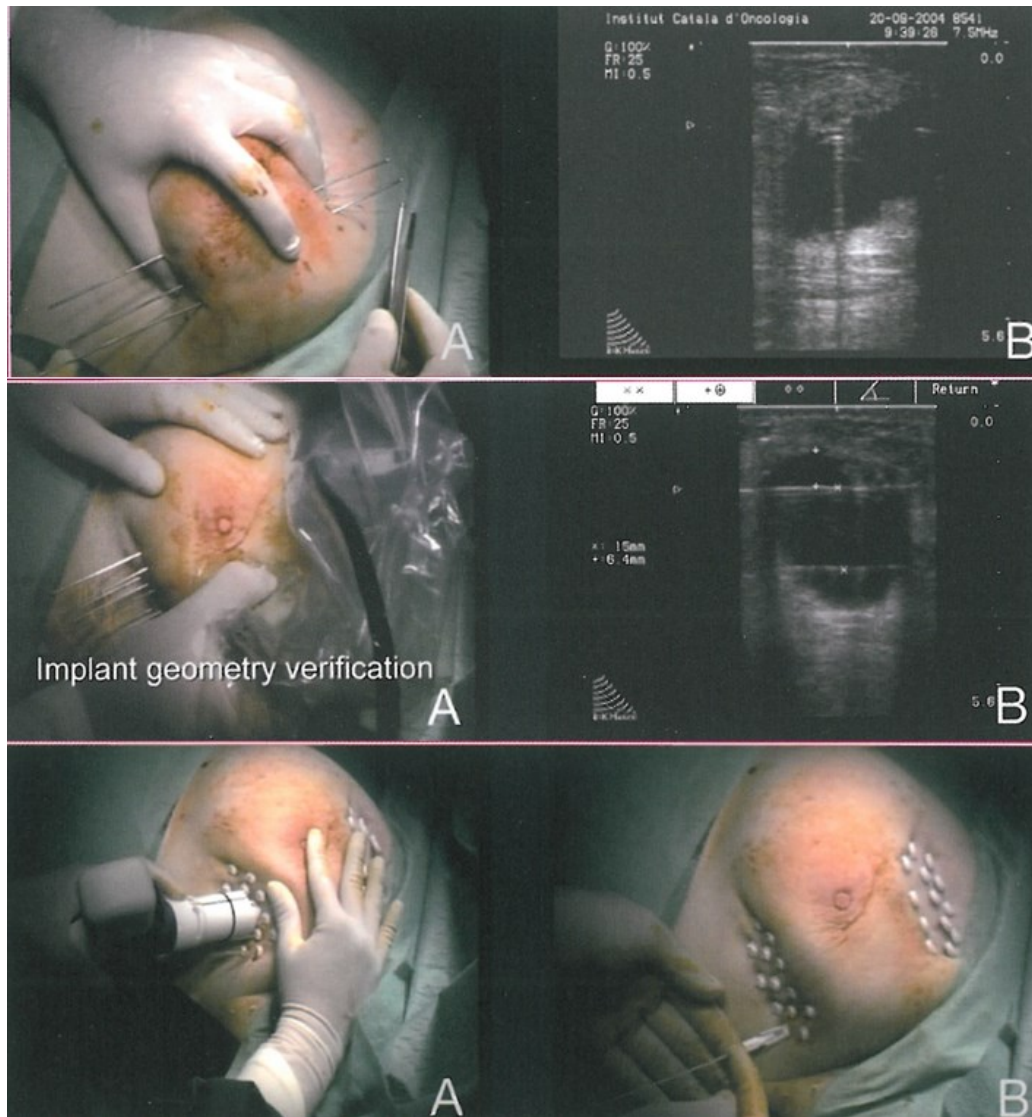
Ultrasound guided implantation with open cavity.
